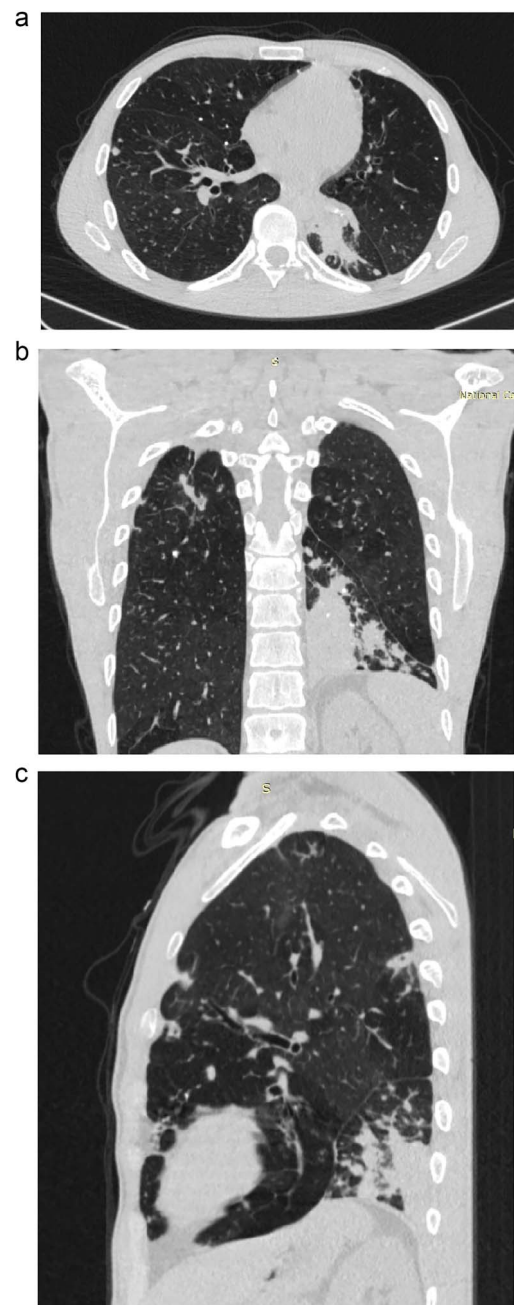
CT scan in axial, coronal, and sagittal section before EVP.
